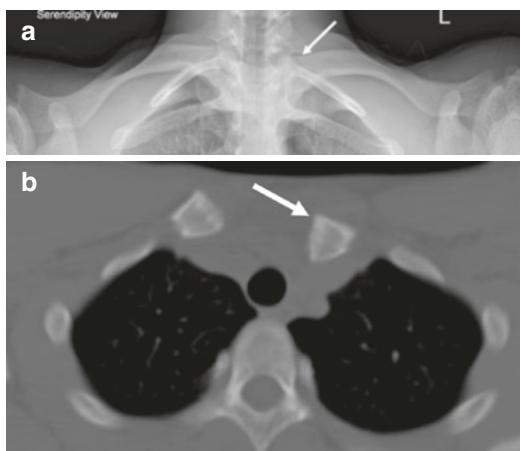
Sixteen-year-old boy with suspected left clavicle injury. AP radiograph (not shown) of the left clavicle is normal. Serendipity view of the sternoclavicular joints (a) shows caudal displacement (arrow) of the left clavicular head at the sternoclavicular junction relative to the right clavicle. This finding is concerning for a posterior dislocation. Because of strong clinical suspicion and abnormal radiographs, CT examination was performed. The axial CT image (b) shows posterior dislocation of the left clavicle. Posterior dislocation can be associated with mediastinal injury, and close examination of the mediastinum is necessary on the CT to exclude such associated injuries
